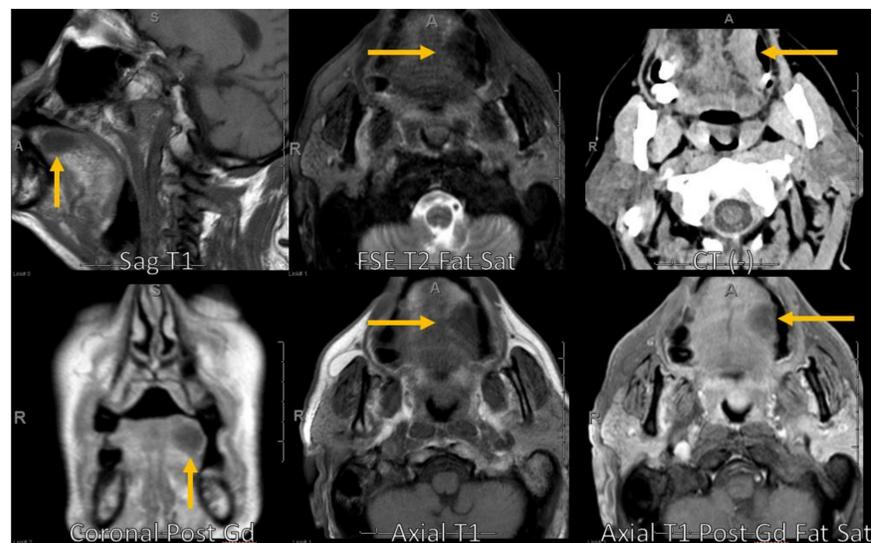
MRI Soft Tissue Neck indicating mass found to be amyloid. MRI read and graphic courtesy of Dr. John Corrigan, HFH Radiology
